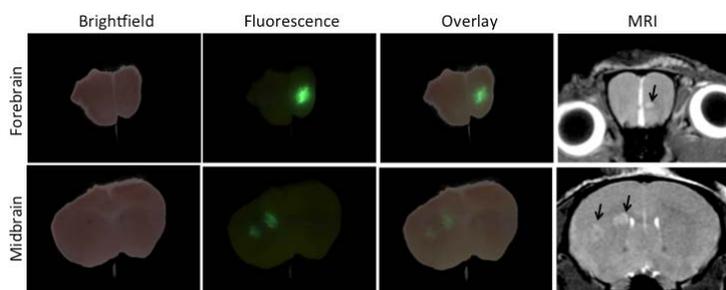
Jint1-BR3 brain tumours imaged by bSSFP MRI were detected as GFP positive growths in CryoViz™ images.
